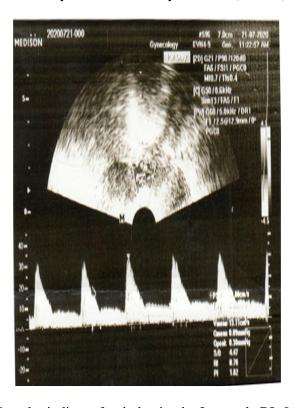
(a) Uterine artery Doppler indices after induction by Letrozole RI=0.78, PI=1.82). (b) spiral artery Doppler indices after induction by clomiphene citrate
